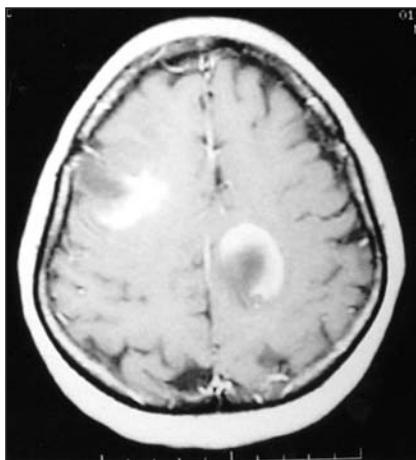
Magnetic resonance image of patient one, showing irregularly enhancing lesions in the right premotor area, and left paracentral area on post contrast T1-weighted image.
